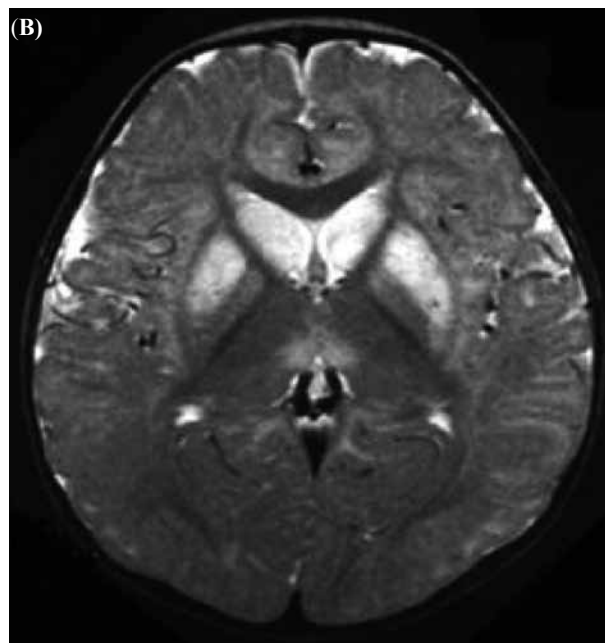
Basal ganglion involvement of brain magnetic resonance imaging (MRI) in syndromic mitochondrial diseases. A. A 4-month-old male infant with deafness dystonia syndrome. Axial 1.5T MRI (TE/TR 93ms/4000ms) showed symmetric involvement of the bilateral putamen. B. An 8-month-old female infant with Leigh syndrome. Axial 1.5T MRI (TE/TR 93ms/4000ms) showed symmetric high signal intensity in bilateral putamen, heads of bilateral caudate nucleus, and periaqueductal area.
